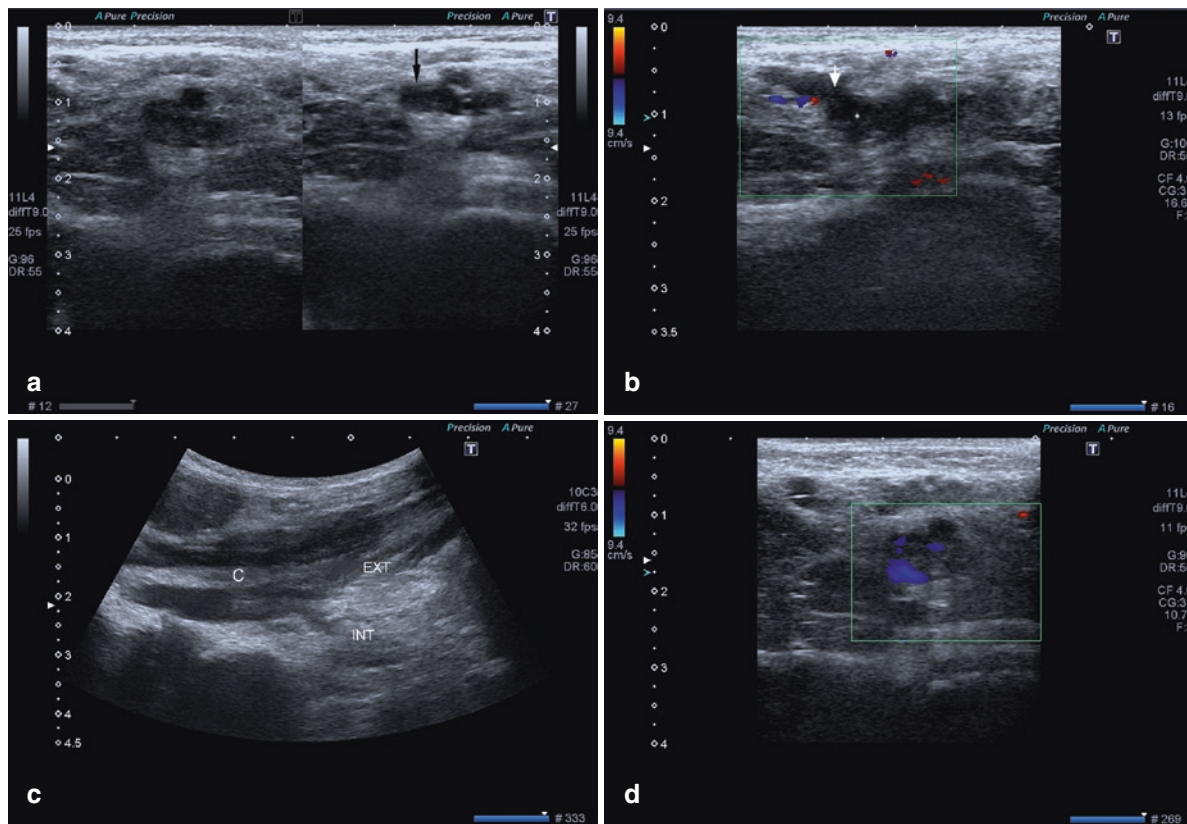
Ultrasound study of acute femoral artery and vein occlusion. (a–d) Acute femoral vein thrombosis. (a) The B-mode ultrasound shows an incomplete compression of the left common femoral vein (arrow). (b) The heterogeneous intraluminal thrombus (star) extends to the greater saphenous cross (arrow). (c) The thrombus is spread to the left internal (INT) and external iliac veins (EXT) up to the common iliac vein C. (d) The colour Doppler study shows a small patent residual
